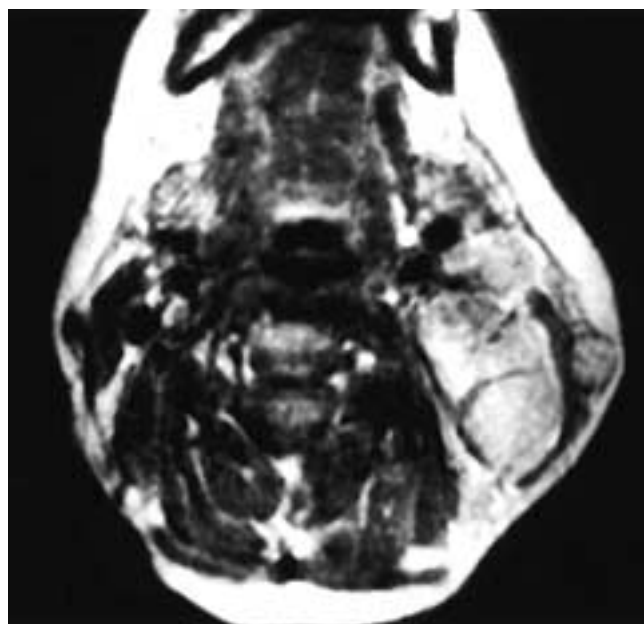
Axial T1-weighted MR image shows multiple enlarged, homogeneous left level II nodes. Although this imaging appearance is most suggestive of lymphoma, this patient had sarcoidosis.
